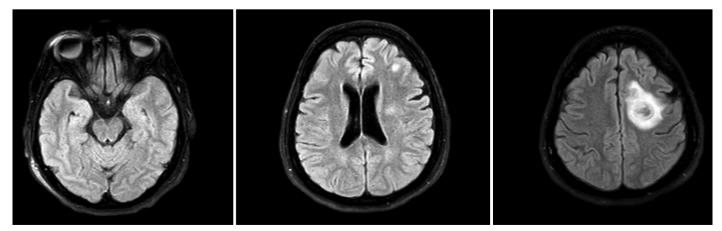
FLAIR-weighted images of patient 4 with cerebral toxoplasmosis after treatment *FLAIR: Fluid-attenuated inversion recovery*
